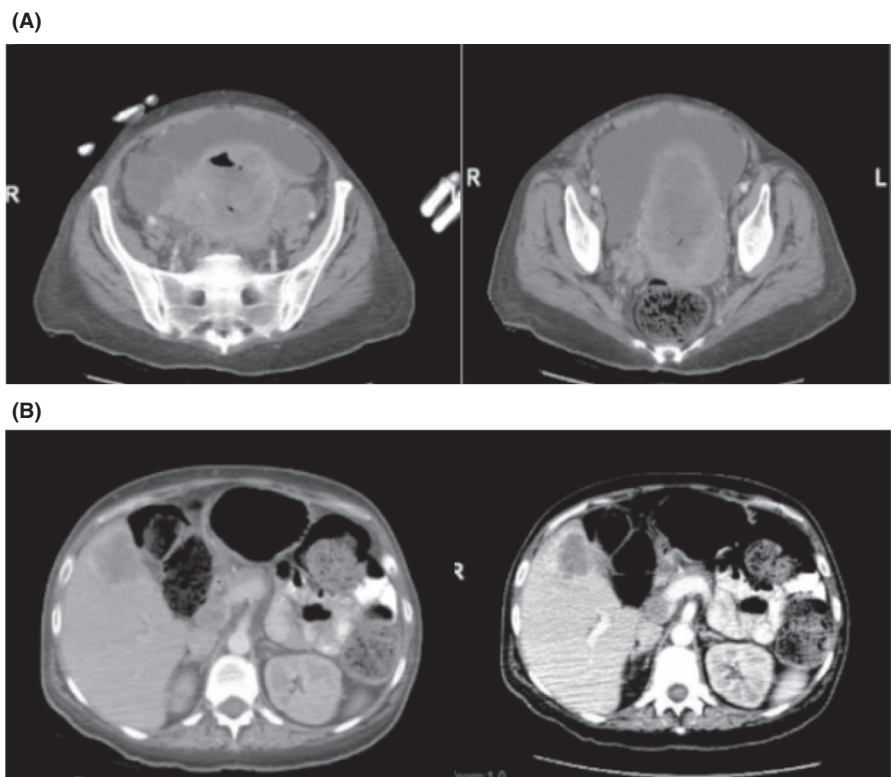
A, B, CT abdomen/pelvis with contrast
